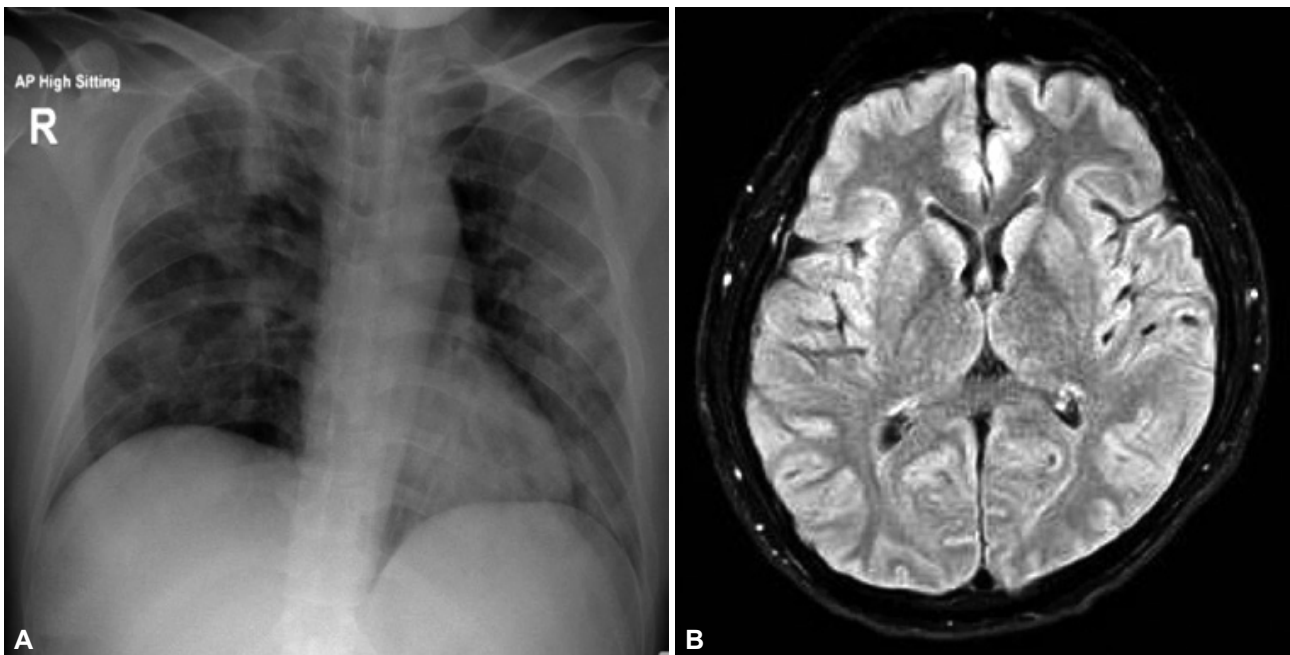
Chest radiography and cranial magnetic resonance imaging of the patient. A: Chest radiography on admission revealed patchy hazy opacities on both upper to lower lungs with peripheral predominance on the left. B: Cranial magnetic resonance imaging with a fluid attenuated inversion recovery sequence was unremarkable.
